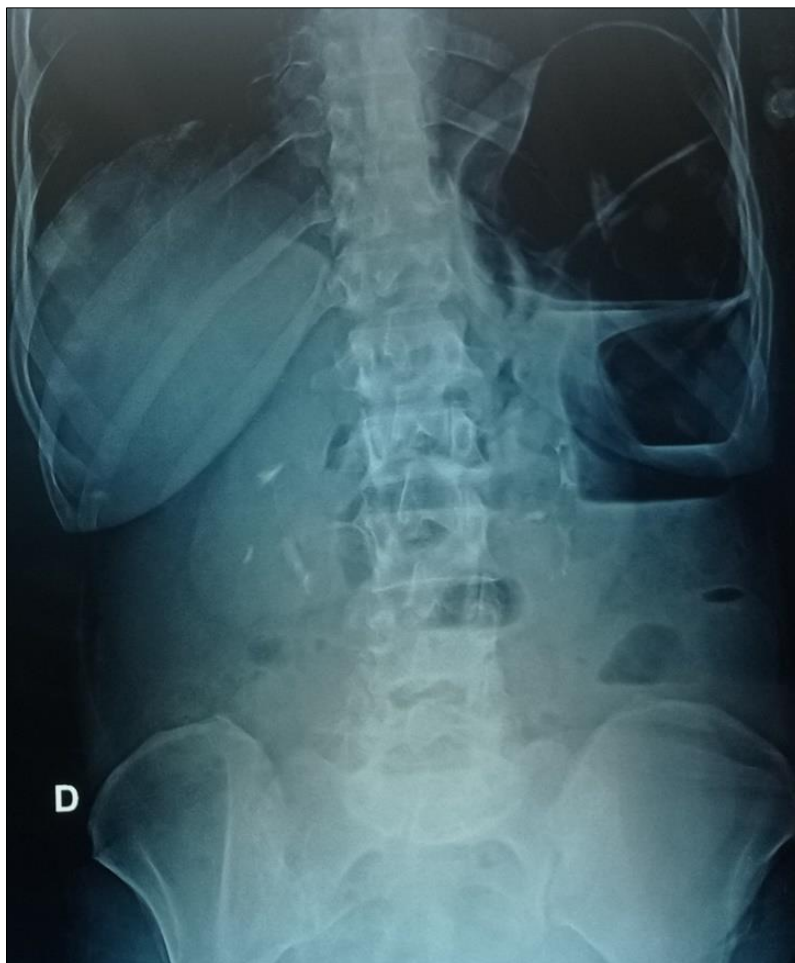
Abdominal x-ray showing air-fluid levels.
